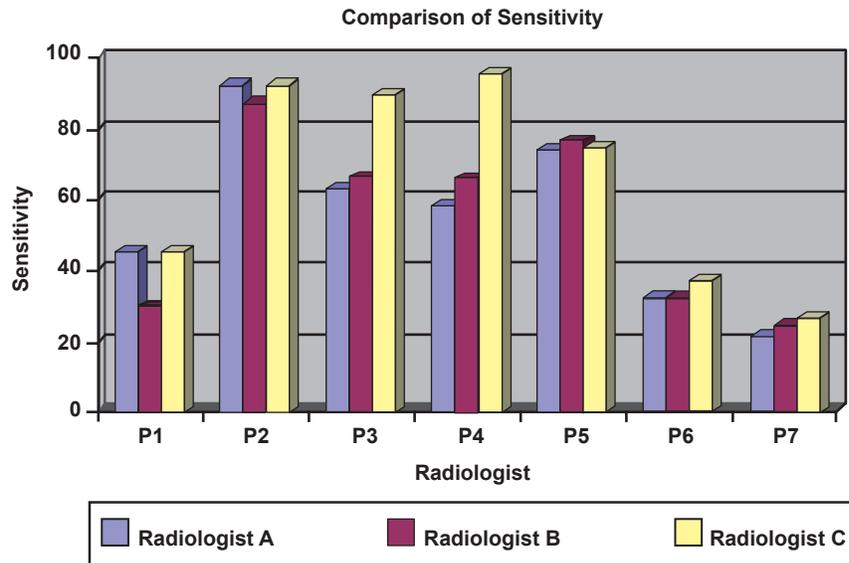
Comparison of the sensitivity of the different CT predictors.
